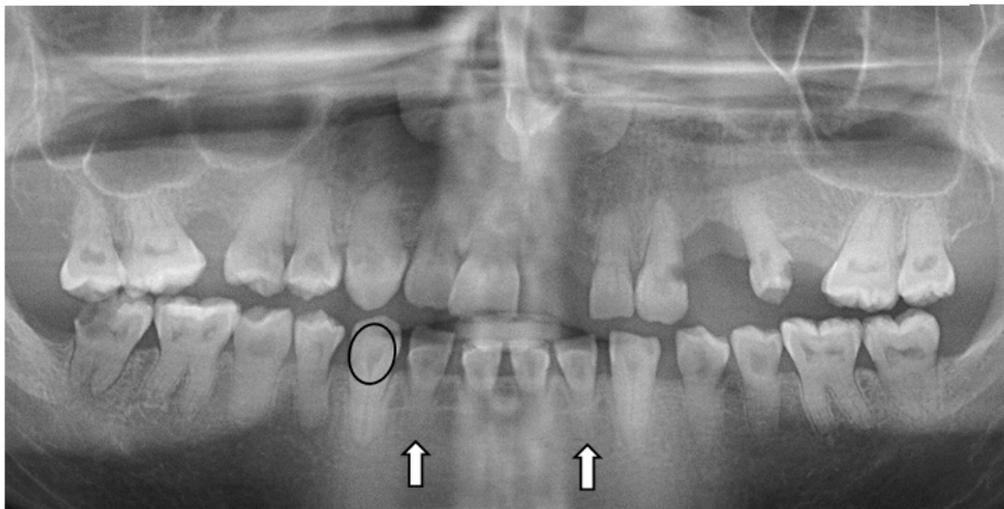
Panoramic radiograph showing short blunted or conical roots of teeth and large pulp chambers
